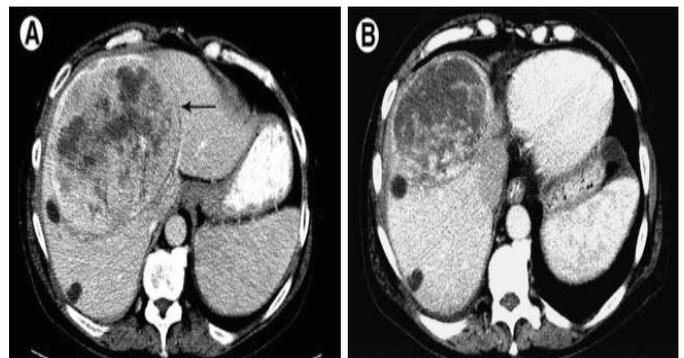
Post treatment assessment. A: Pretreatment computed tomography (CT) shows a large central hypervascular lesion (black arrow); B: CT 3 months after SIRT showing a significant reduction in lesion size [10].
